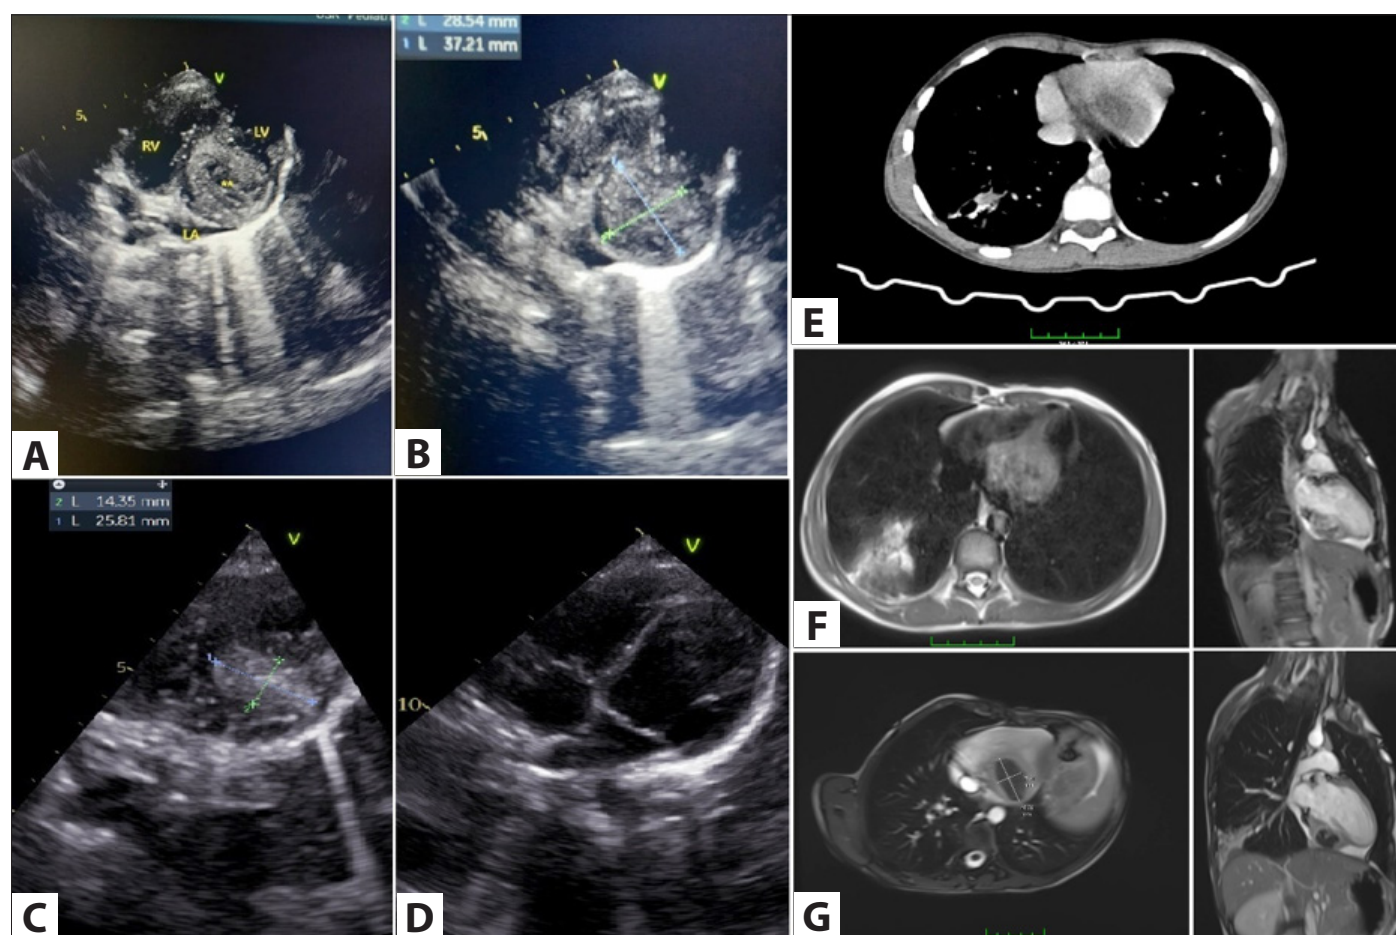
Echocardiographic examination: Echocardiography revealed a 37 x 28 mm cystic lesion with hypoechoic foci located posteriorly to the left ventricle. The lesion exhibited a well-defined border, involved the posterior wall, and induced mild pericardial effusion (A,B). Three months post-operatively, follow-up echocardiography demonstrated marked shrinkage of the lesion following implosion ablation. The central cystic appearance had resolved, the circumference was clearly demarcated, and the left ventricular cavity was unrestricted (C,D). Cardiac CT examination showed normal cardiothoracic ratio and heart chambers, but a hypodense oval mass lesion with septation, compatible with hydatid cyst was observed at the left ventricular-diaphragm border (E). Cardiac MRI examination showed a circumferential contrast-enhancing lesion located in the left ventricular myocardium, approximately 4 x 2 cm in size, hypointense on T1 and T2A sequences after IVKM injection (F,G).
